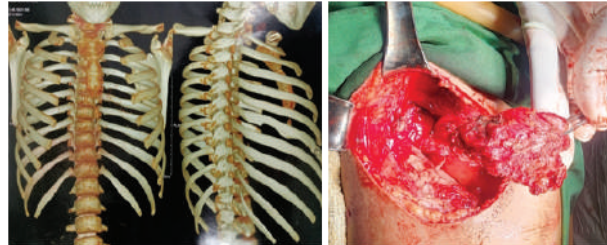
(a) CT scan of Rib lesion (b) Excision of Rib lesion
